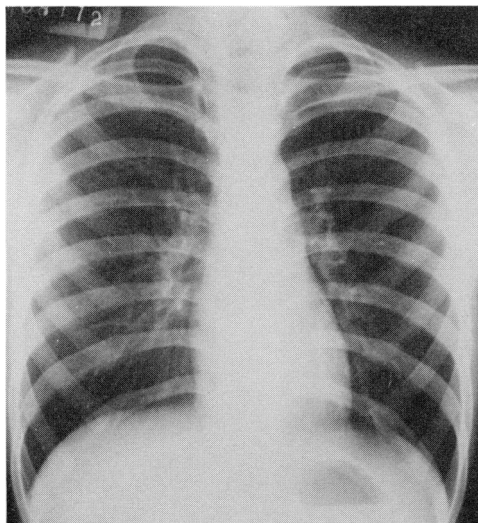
Chest X-ray film seven days later (Case 1).
